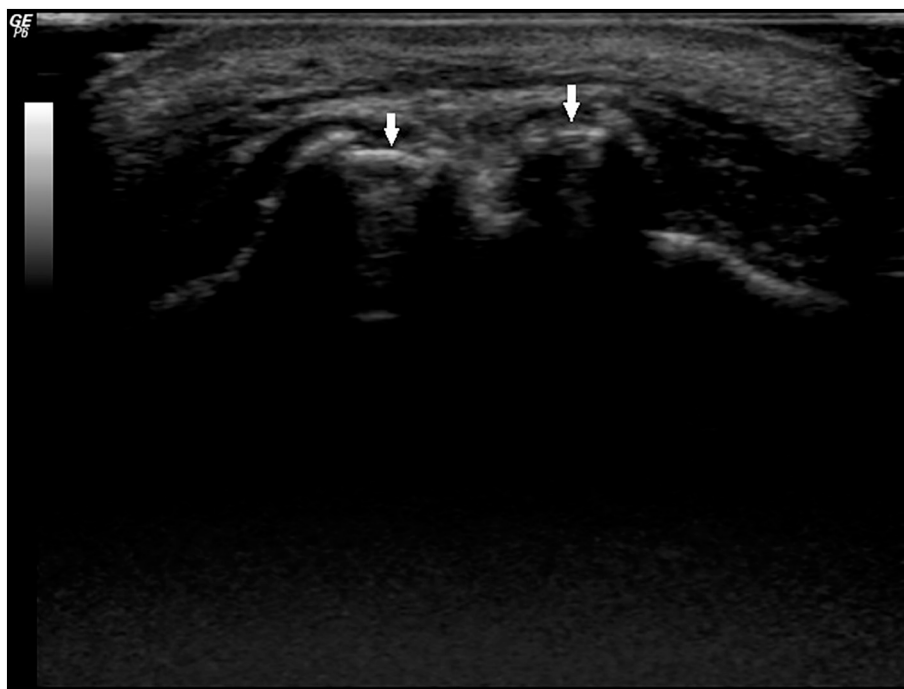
Ultrasound performed using a high frequency (10–13 MHz) probe revealed two linear echogenic structures with posterior acoustic shadowing (arrow) in the upper part of gingiva (above the level of cervical aspect of other normally lying adjacent teeth) suggestive of tooth intrusion.
